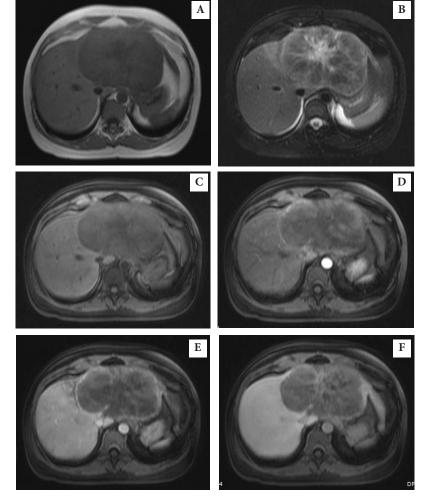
(A) T1-weighted gradient echo image and (B) T2-weighted fat saturation image show a large lobulated mass at almost entire left hepatic lobe. This mass has hyposignal intensity on both T1W and T2W images. Notice the central scar which has slightly hypointense signal intensity on T1W and hyperintense signal intensity on T2W. On dynamic contrast study (C)-(F), this mass shows irregular enhancement on the arterial (D) and equilibrium phase (E). No enhancement of the central scar is noted. No uptake of hepatocyte specific contrast agent is demonstrated on delayed phase (F).
